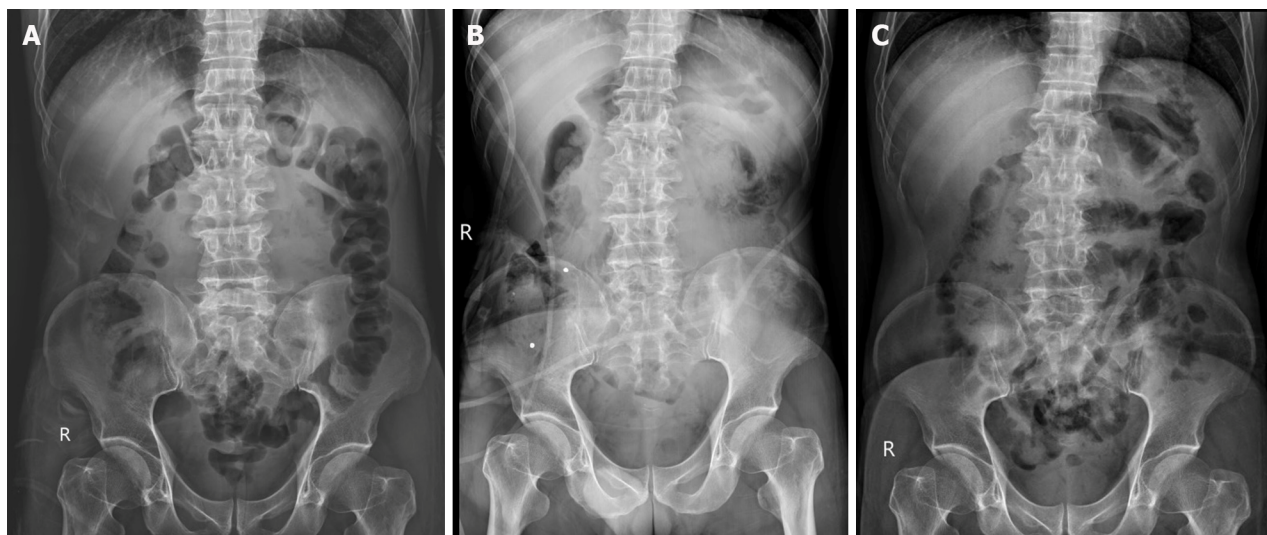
Abdominal X-rays. A: Gasless small bowel from X-ray in 1st visit; B: Small bowel devoid of gas observed on the fifth day after the completion of a colonoscopy procedure; C: Disappearance of gasless small bowel after operation.
